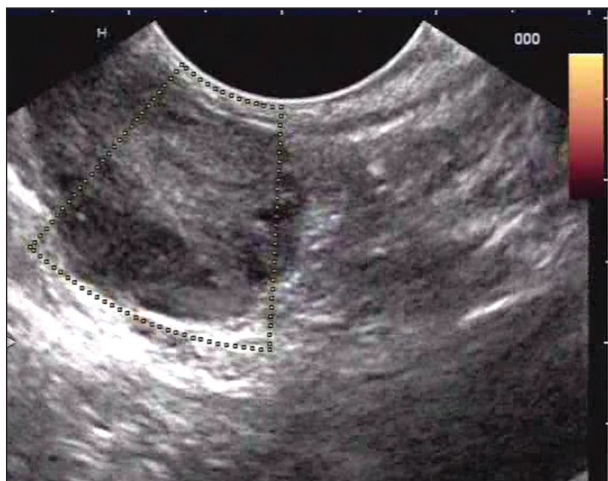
No increased vascularity seen on power Doppler
